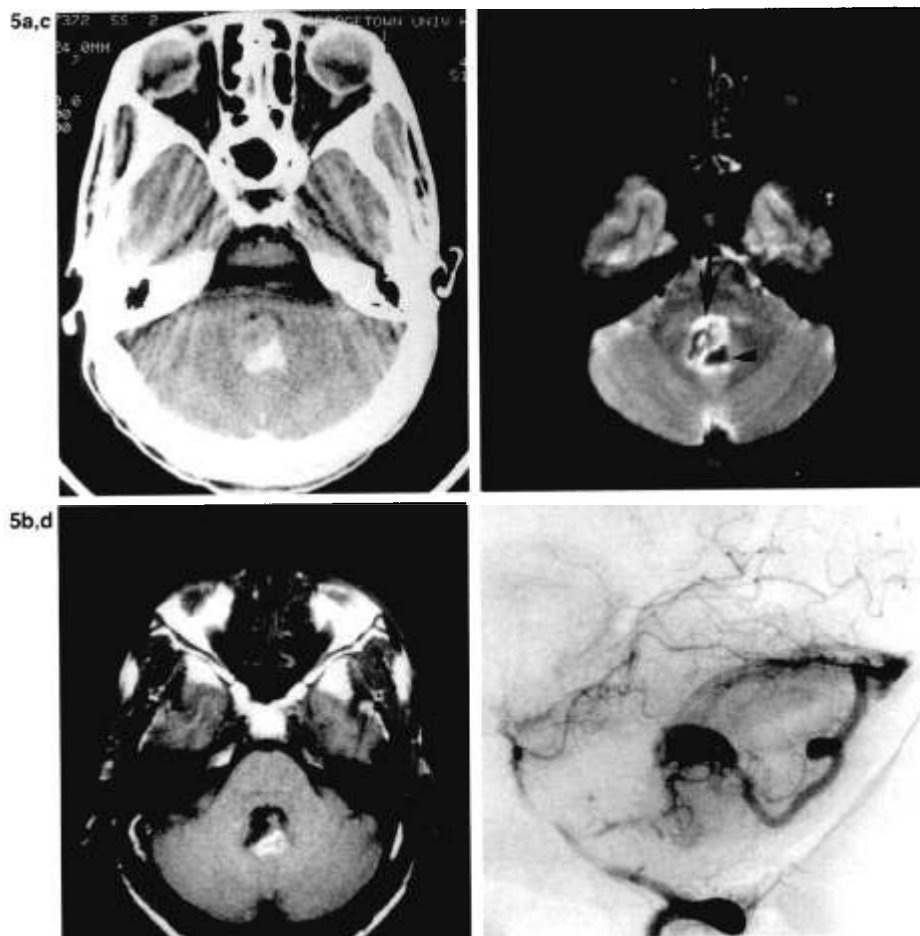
Four day posterior fossa hematoma at 1.5 T. a: Posterior fossa noncontrast CT scan 2 days after sudden onset of symptomatology consistent with intracranial bleeding in a patient with arteriovenous malformation (AVM) close to fourth ventricle. Blood collection at site is obvious. b: Two days later, T1-weighted image (TR 600/TE 15 ms) shows isointense (to cerebellum) centrum with peripheral hyperintensity as methemoglobin begins to form. Markedly hypointense areas anterior to extravasated blood are AVM vessels (flow). c: T2-weighted image (TR 2,500/TE 80 ms) shows marked hypointensity in center of hematoma (arrowhead) as deoxygenation is probably complete. Irregularly distributed edema and compressed slit-like fourth ventricle (arrow, also see CT) appear as hyperintense areas. Note also flow void effect in adjacent AVM vessels. d: Arteriogram.
